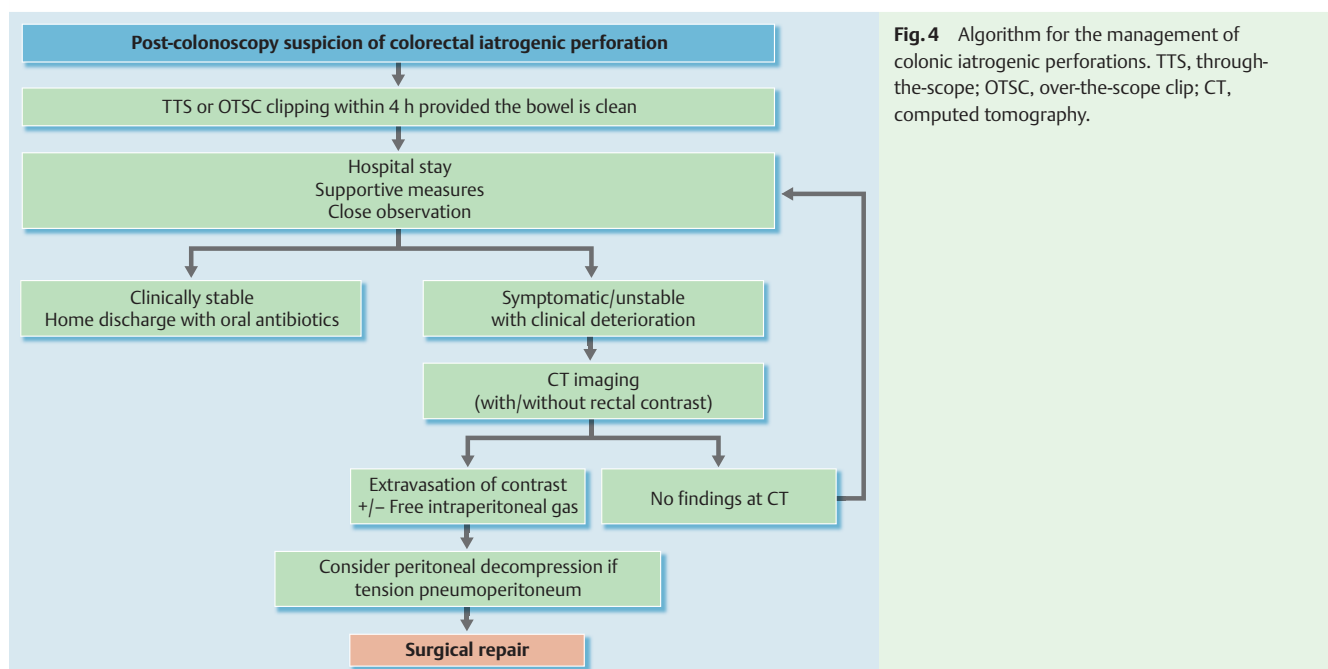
Algorithm for the management of colonic iatrogenic perforations. TTS, through-the-scope; OTSC, over-the-scope clip; CT, computed tomography.
